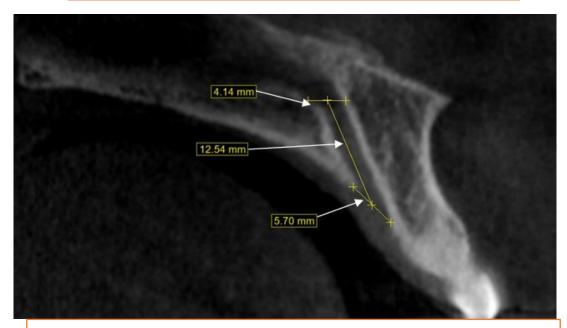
Sagittal CBCT image revealed dimensions of the NPC
